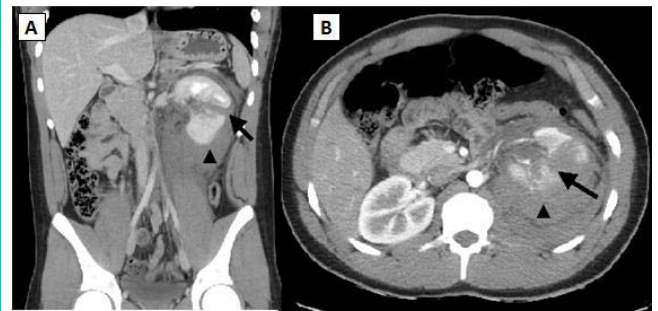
Case 2. CT scan performed immediately after the trauma. Contrast-enhanced nephrographic-phase helical CT scan shows a complete laceration of left renal parenchyma (arrows) and perirenal collection which corresponds to a hematoma (arrowheads).
